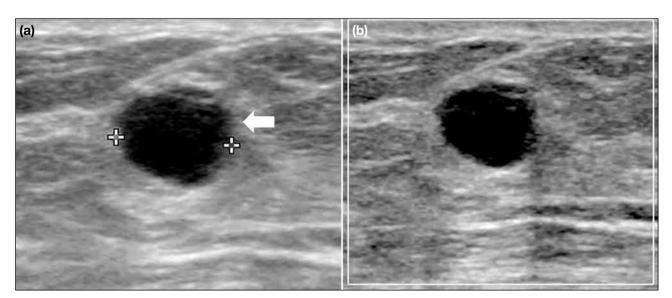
A 23-year-old lactating female presented with a palpable lump in the left breast at 10 o'clock position. (a) Targeted ultrasound (US) in transverse plane shows a hypoechoic and anechoic lesion with a fat-fluid level (arrow) and posterior acoustic enhancement. (b) Doppler US study shows no internal vascularity. Fine needle aspiration confirmed the diagnosis of galactocele.
